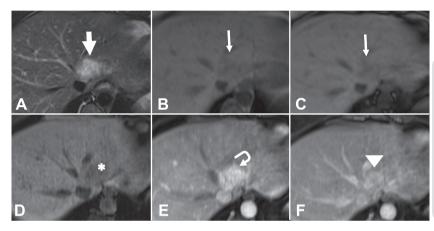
Suspected hepatic adenoma. MRI showing usual imaging features of inflamatory adenoma, presented as an hyperintense heterogeneous nodule (thick arrow) on T2-weitghted image (A), with no fat (thin arrow) on in-phase (B) and out-of-phase (C) images. The nodule is hypointense (asterisk) on pre-contrast phase (D), with intense enhancement (curved arrow) on arterial phase (E), that persist hyperintense (arrowhead) on portal-venous (F) and delayed phase (not shown)
